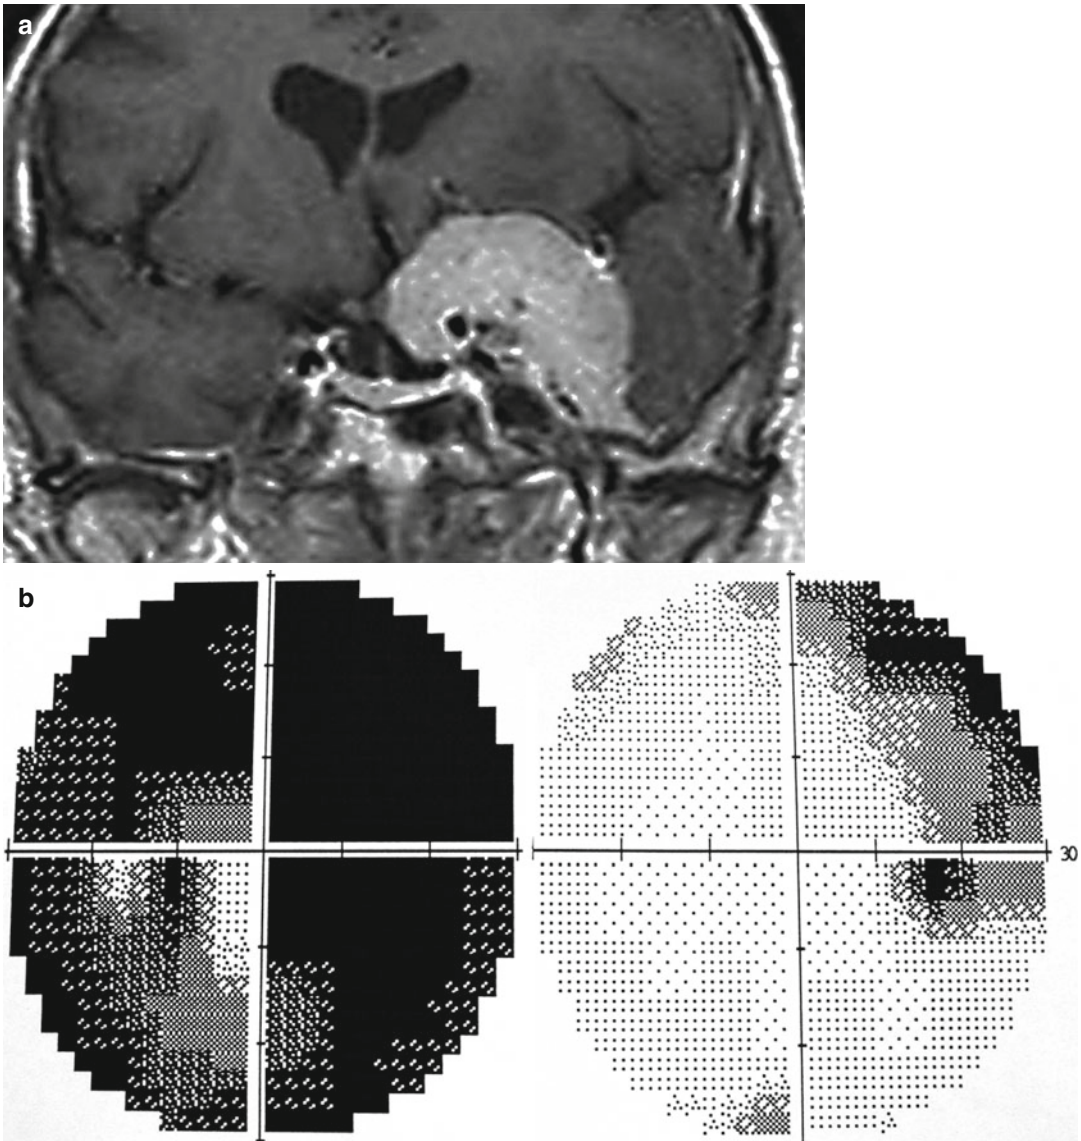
(a) Coronal MR image of a left sided parasellar meningeoma. (b) Visual field defect caused by a prechiasmatic chiasm lesion (junctional scotoma): left sided optic lesion + contralateral superior temporal quadrantanopia
